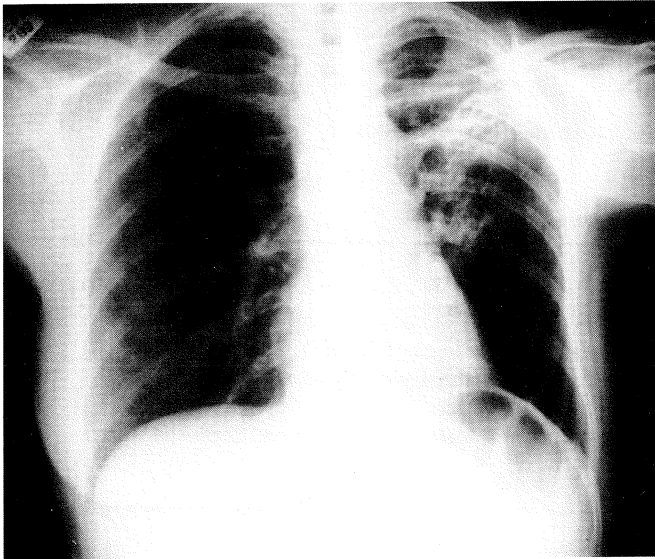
Chest roentgenogram in February 1986. A irregular cavity (2.5 cm) surrounded by opacification and containing mass or liquid, may be seen in the left upper lobe.
